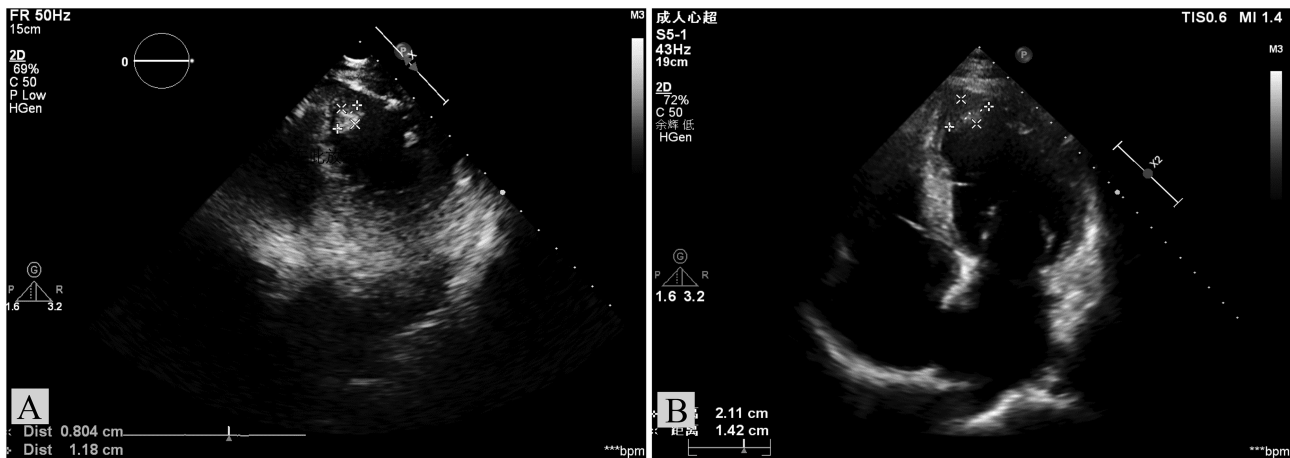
Results of transthoracic echocardiography. Parts (A) and (B) were taken on 22 May 2017 and 13 May 2019, respectively, showing a 0.8×1.18 cm and a 2.11×1.42 cm echogenic mass suggestive of left ventricular thrombus.
